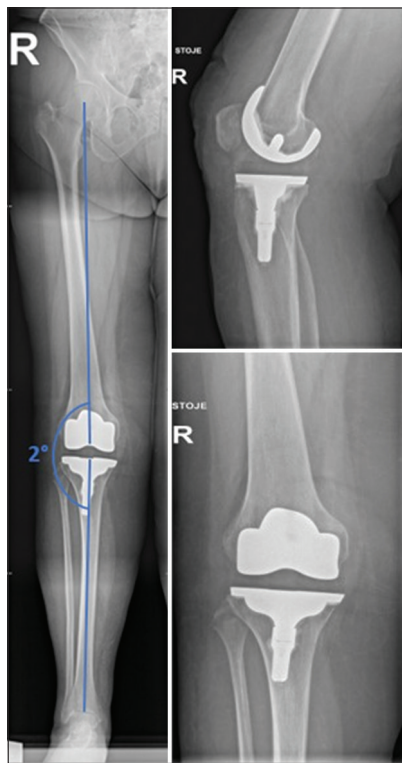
Standing right leg long leg anteroposterior view X-ray and right knee X-ray in anteroposterior and lateral view
